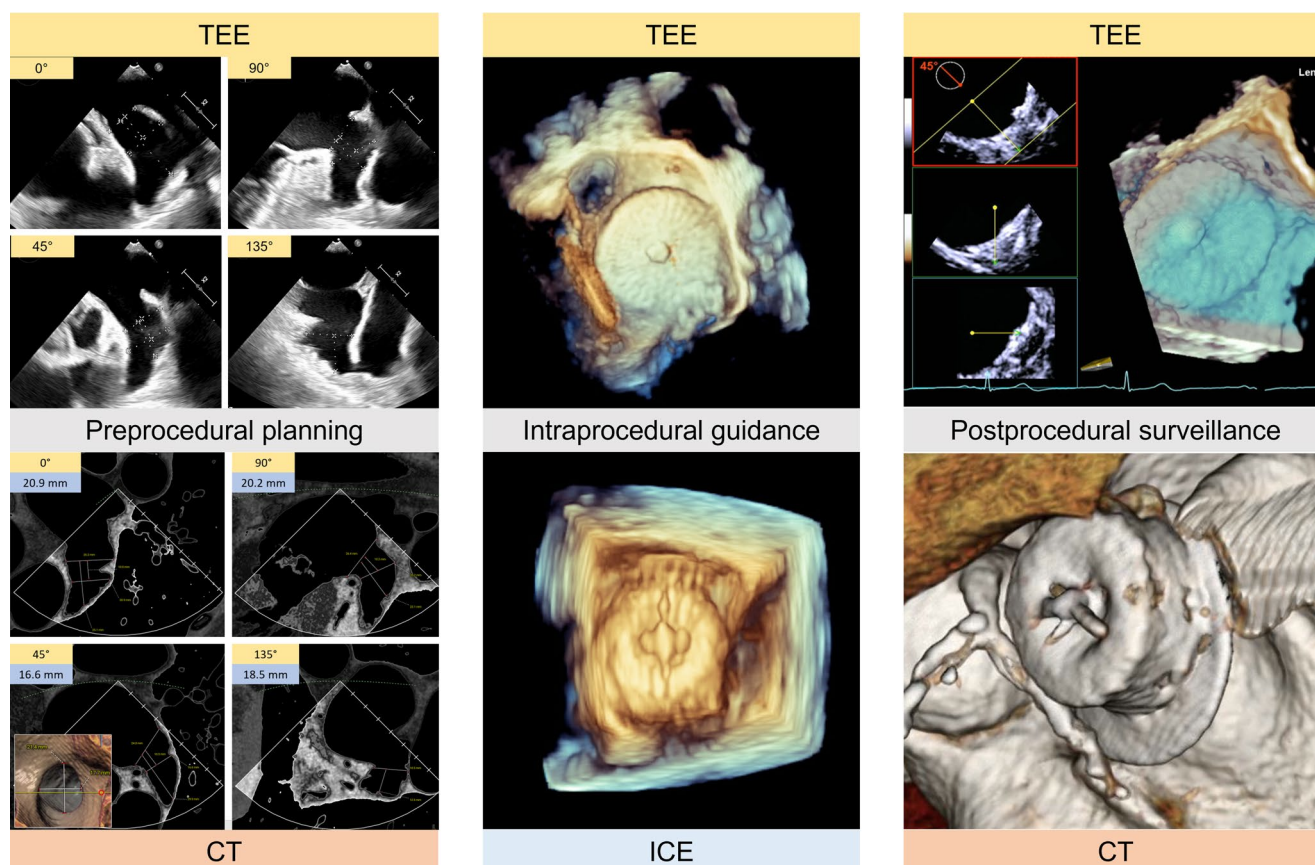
Multimodality imaging of left atrial appendage occlusion across three phases of care. Key: CT, computed tomography; ICE, intracardiac echocardiography; TEE, transesophageal echocardiography
